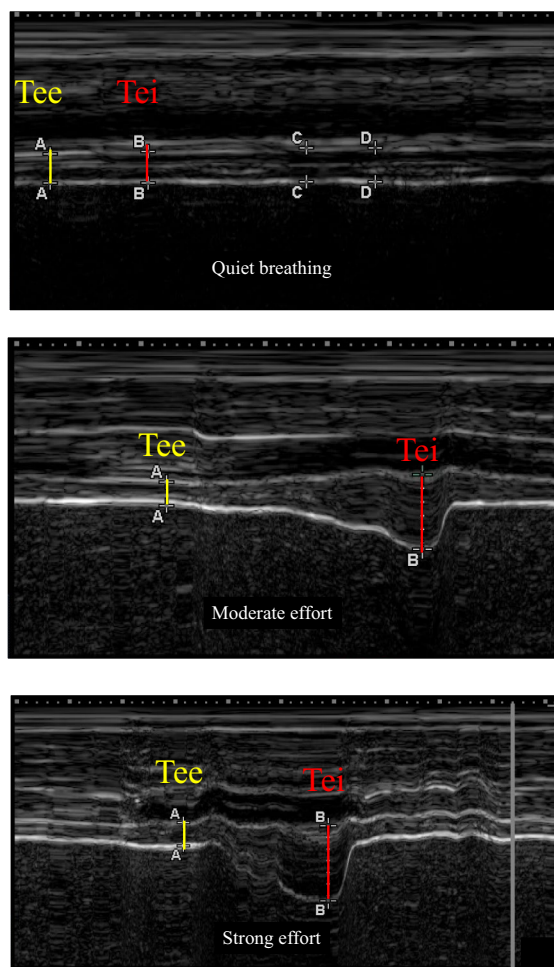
Diaphragm ultrasound using time-motion mode at three different conditions: quiet breathing, moderate inspiratory effort, and strong inspiratory effort. Note the increase in diaphragm end inspiratory thickness (*Tei*) at moderate and strong inspiratory effort. *Tee* end expiratory thickness, *Tei* end inspiratory thickness
